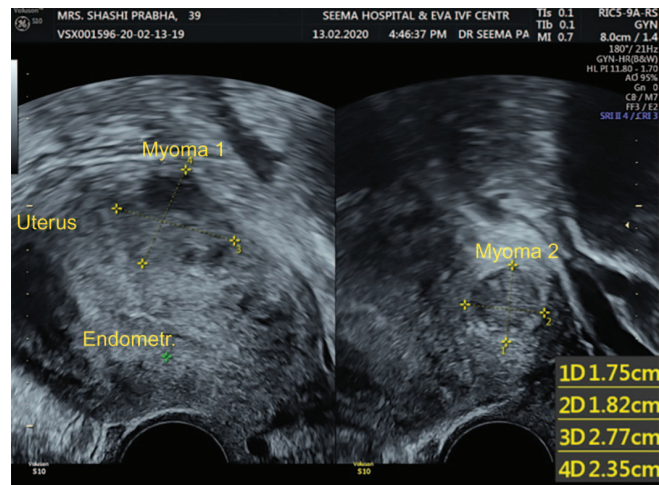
Ultrasound image showing multiple myomas
